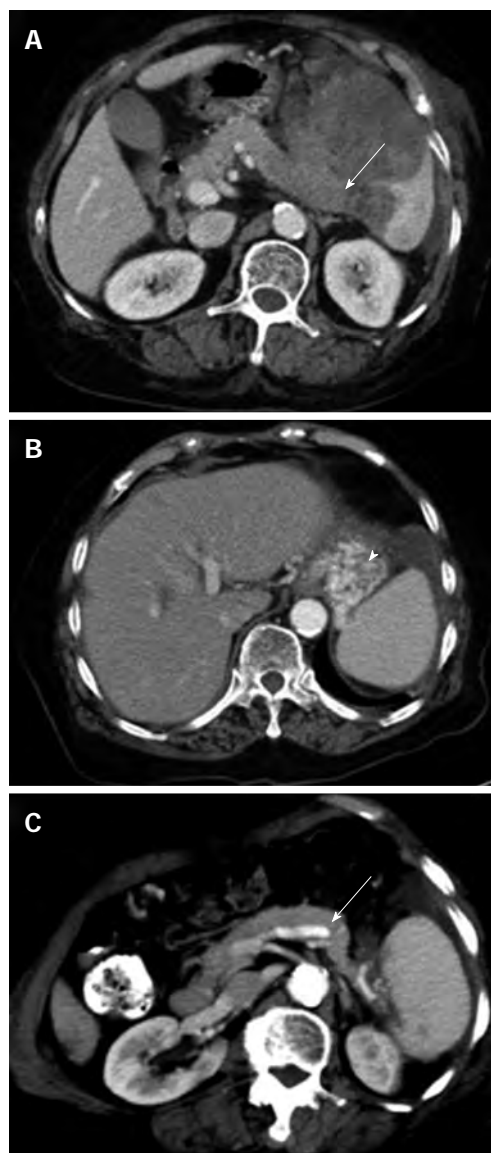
Imaging findings. A: Axial contrast-enhanced abdominal computed tomography (CT) at the level of the splenic hilum shows a large low-attenuation mass in the enlarged spleen. The mass involves the splenic vein with near total occlusion (arrow); B: The development of a gastric varice (arrowhead) at the fundus; C: The 6-mo follow-up CT shows that the splenic mass has almost completely resolved, allowing the splenic vein (arrow) to return to patency.
